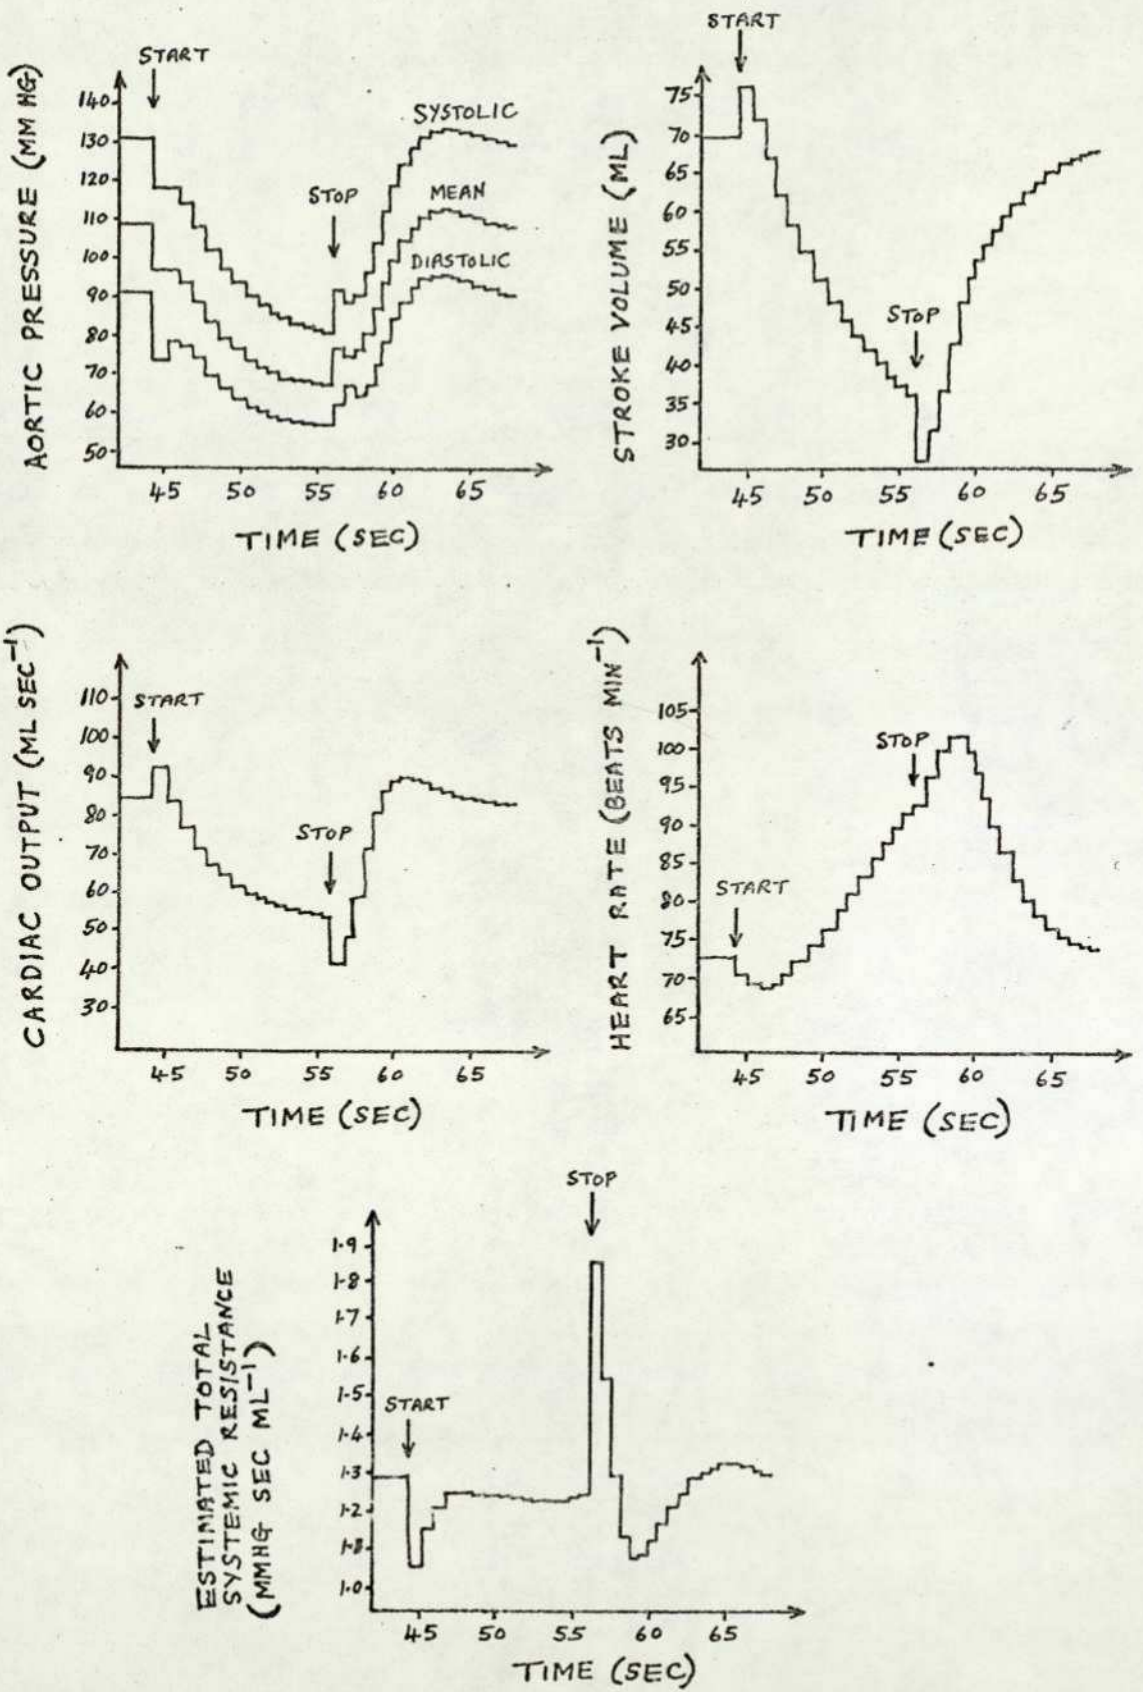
THE DYNAMICS IN A VALSALVA MANOEUVRE. THE MANOEUVRE STARTS AT $t=44$ sec WITH $P_{TH} = P_{ABD} = +40$ mmHg AND STOPS AT $t=56$ sec WITH P_{TH} AND P_{ABD} RETURNING TO NORMAL VALUES OF -4 mmHg AND $+4$ mmHg RESPECTIVELY.
